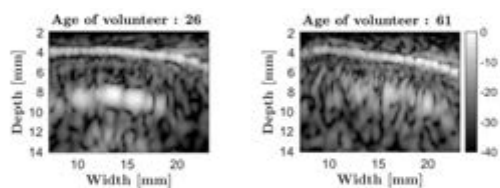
Typical *in vivo* ultrasound images of young and elderly volunteers. The echographic probe was placed on the tibia transversely to the bone axis. The bright line around 4 mm is the periosteum. Left: the bright region around 9 mm is the endosteum and is clearly visible for this young subject. Right: the endosteum is less visible for an older subject.
